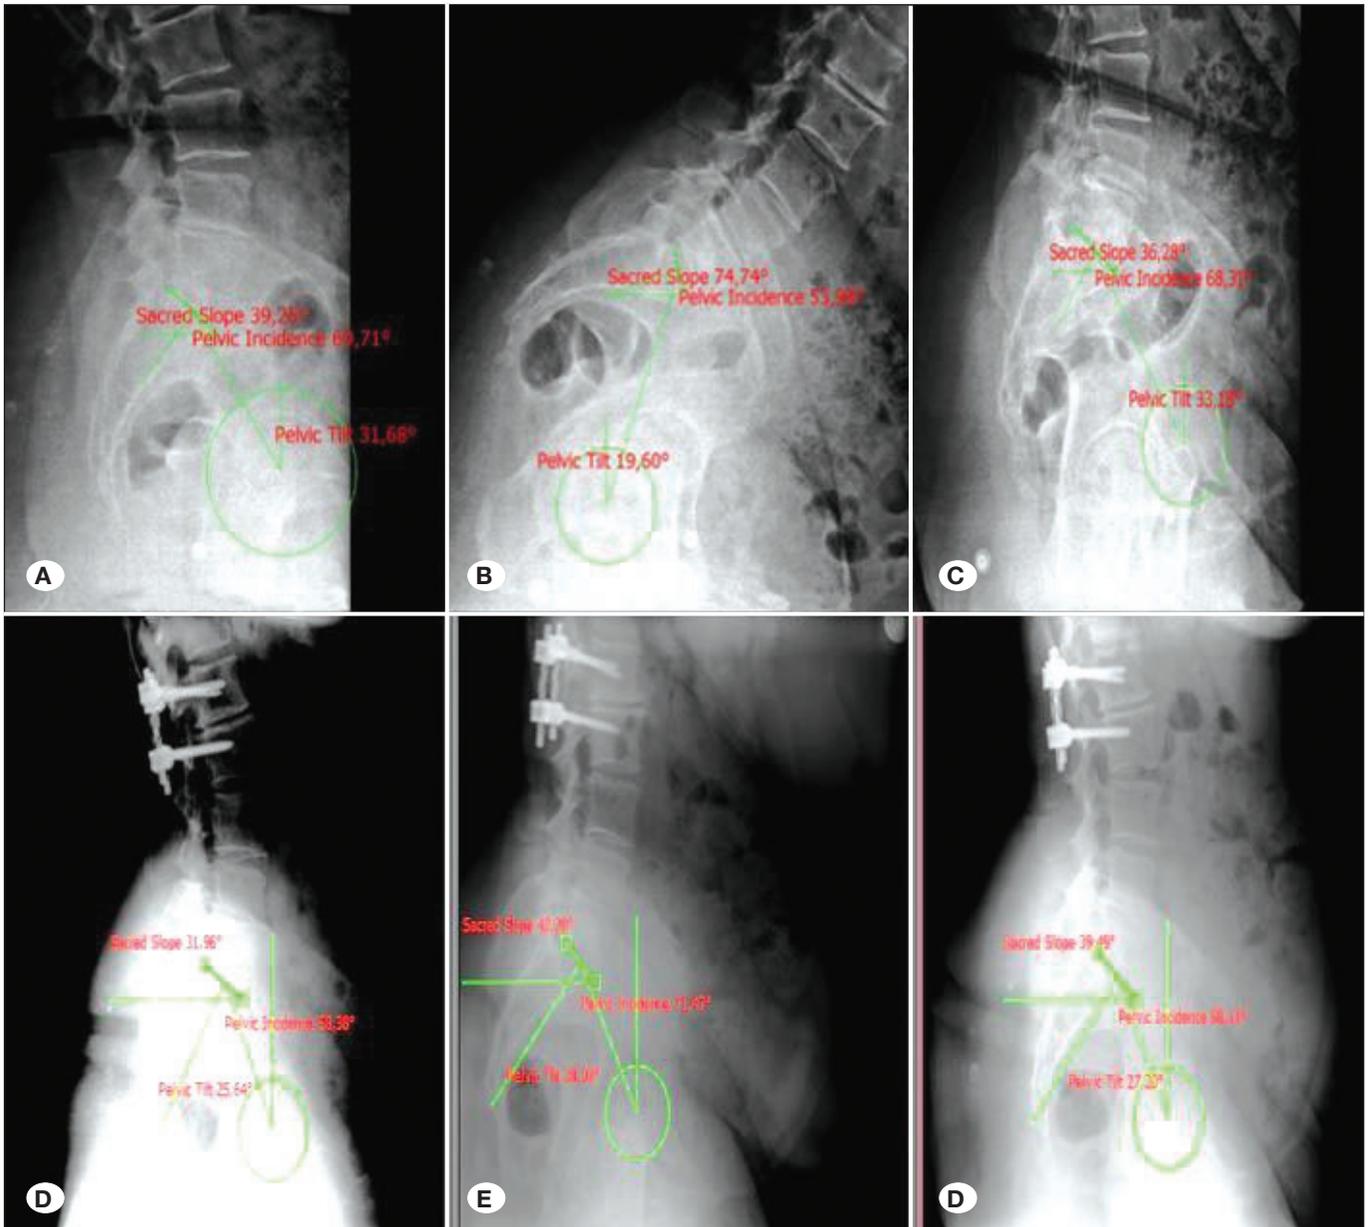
Lateral lumbar spinal radiographs of a patient in neutral (A), flexion (B), and extension (C) positions before surgery. Neutral (D), flexion (E) and extension (F) radiographs (including measurements) of a patient who underwent surgery for lumbar (L) 1-2 extruded disc herniation. Discectomy and dynamic posterior stabilization was performed.
